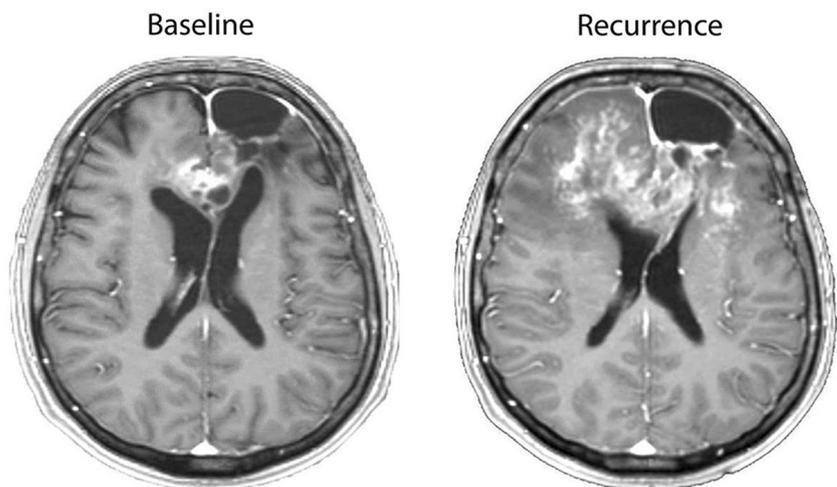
Exemplary tumor recurrence on regorafenib treatment as evidenced on MRI (contrast-enhanced T1 sequence) is shown for a patient, where tumor size increased 453% as compared to baseline
